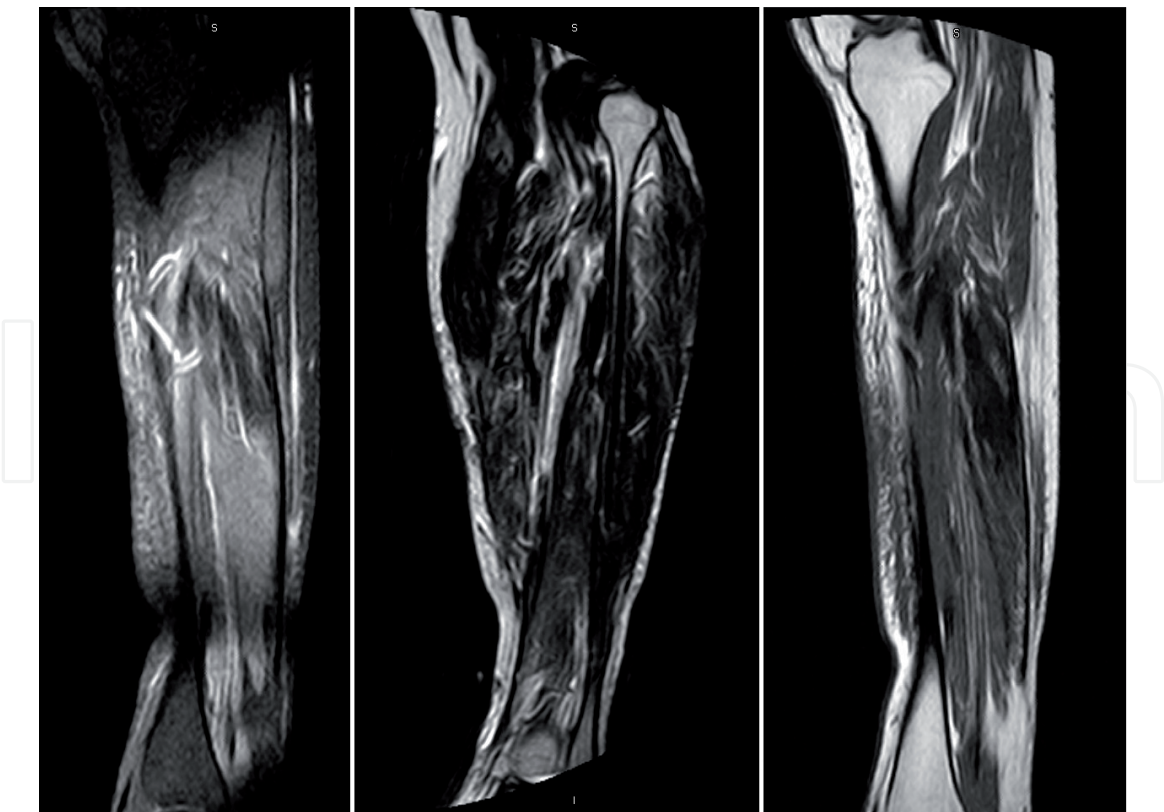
Magnetic resonance imaging showing sequelae of the compartment syndrome after 6 months: the presence of a certain degree of discrete muscular oedema in a trajectory of approximately 18 cm is observed, affecting the soleus muscles, with a chronic appearance. There is a certain degree of fat infiltration mainly in the proximal third of the muscle mass. Likewise, an apparent degree of scarring and / or fibrosis is also detected in the muscle. The fascia signal is preserved.
